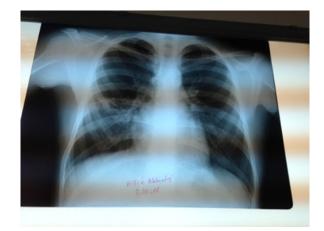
Chest X-ray 4 years after surgery.
